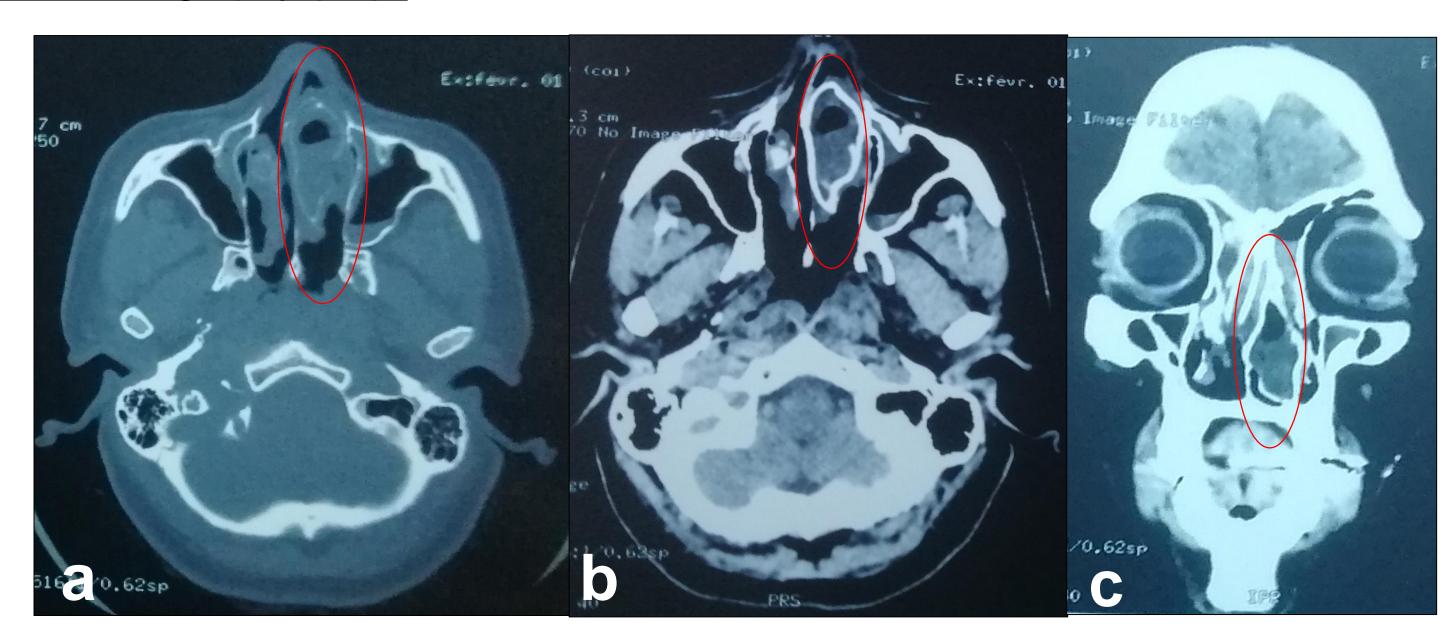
CT axial (a,b) and coronal (c) images showing a giant concha bullosa. Left osteomeatal complex was obliterated. Partial opacification of the maxillary, right frontal and sphenoidal sinuses was noted.
